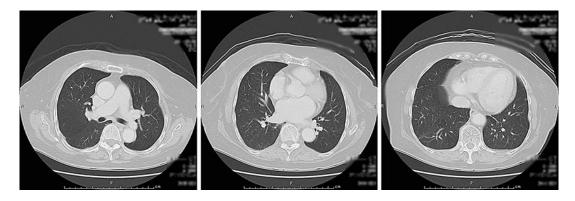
After 17 courses of treatment, the pulmonary metastases had disappeared, and no new lesions were detected by computed tomography.
